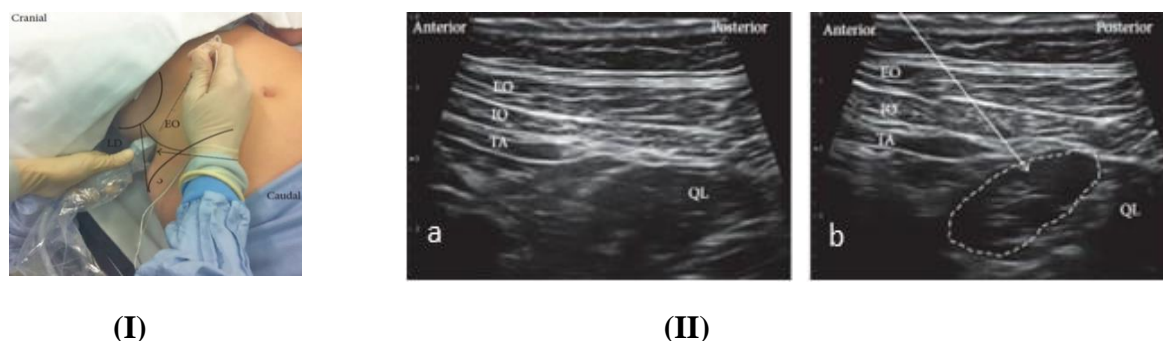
Lateral quadratus lumborum block approach: I probe position, II Ultrasound images (a) Pre-injection and (b) post-injection. EO: external oblique muscle, IO: internal oblique muscle, TA: transversus abdominis, QL: quadratus lumborum, white arrow: needle trajectory and white dotted line: the spread of local anesthetic (36).
